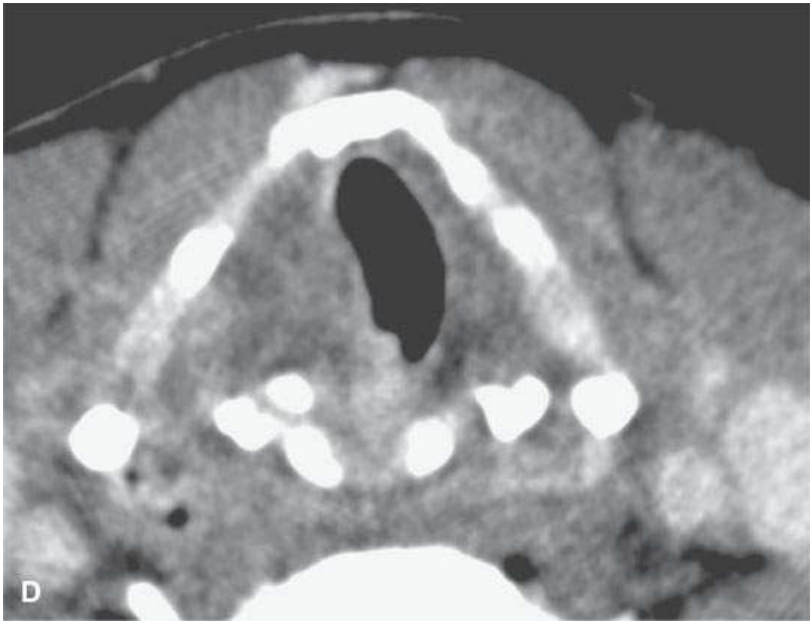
Contrast-enhanced computed tomography showing the range of enhancement possible in various epithelial-origin mucosal-based cancers. A: Adenoidcystic carcinoma of the tongue base. Note how this microcystic lesion is slightly lower in density than muscle (*arrow*). B: Tongue base squamous cell carcinoma (SCCA) showing areas of variable enhancement (*arrows*). C, D: Mixed pattern of enhancement in this poorly differentiated laryngeal cancer. E: Fairly brisk enhancement in this posterior oral tongue SCCA that was ulcerative clinically (*arrow*).
